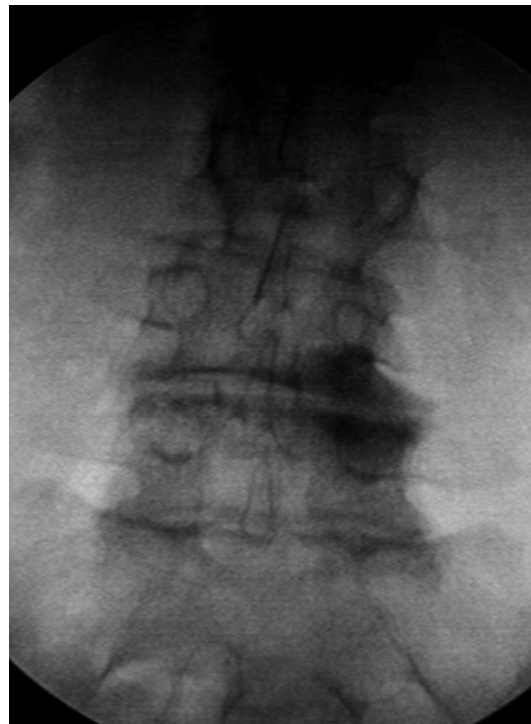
Plain radiography with severe osteoarthritis L4–L5
